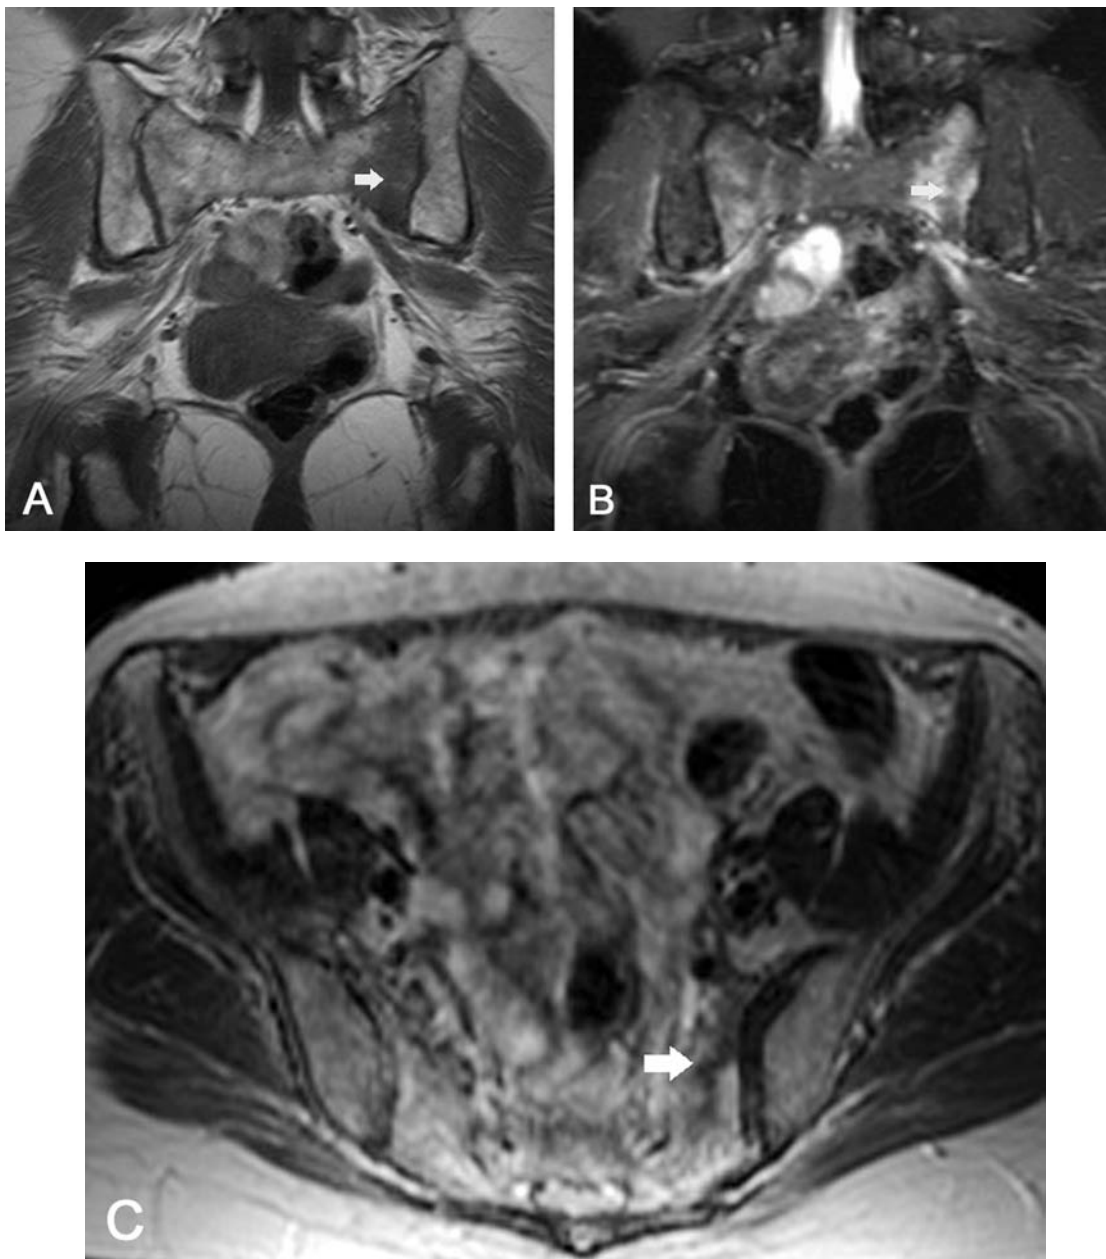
A. Coronal T1-weighted image of the sacrum showing nonspecific loss of normal fatty signal intensity on the left side of the sacrum (arrow). B. Coronal T2-weighted image of the sacrum with fat suppression, same plane as panel A, shows high signal intensity in the same area of the sacrum (arrow), but similar finding on the right side as well, consistent with edema. C. Axial T2-weighted image of the sacrum showing linear area of low signal intensity (arrow) on the left edematous reaction of the sacrum, consistent with a discrete fracture.
